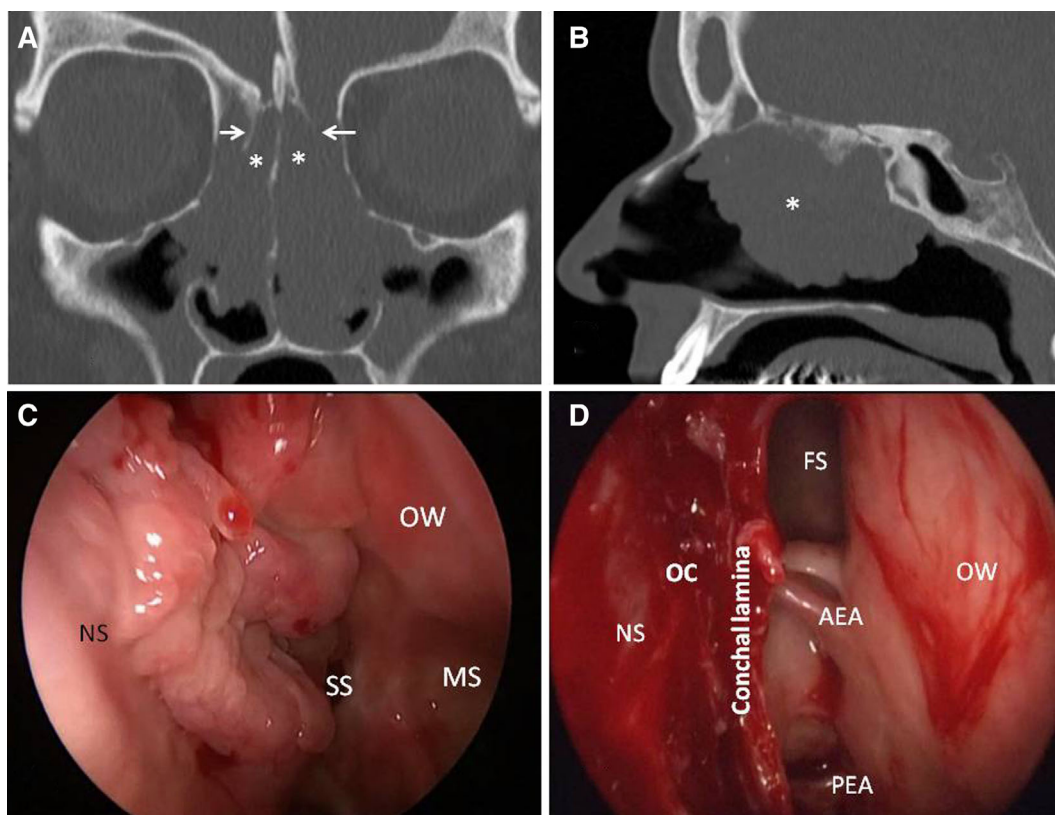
Patient with history of nasalization with middle turbinate resection and large opening of all paranasal sinuses 17 years ago. The first revision surgery was performed 17 years after nasalization. (A) Coronal CT scan before revision surgery showed voluminous polyps developing essentially inside the olfactory clefts (white asterisks) which were widened and pushed laterally the conchal lamina (white arrows); (B) Sagittal CT scan of the left nasal cavity showed voluminous polyps stemming from the olfactory cleft; (C) Per-operative endoscopic aspect of the left nasal cavity of this patient at revision surgery: huge polyps stemming from the left olfactory cleft; (D) Endoscopic aspect of the left nasal cavity after removal of polyps: polyps were observed only inside the olfactory cleft, the mucosa of left ethmoidal complex was free of polyp recurrence. Pathological results confirmed a huge REAH with some small inflammatory polyps. AEA = anterior ethmoidal artery; CT = computed tomography; FS = frontal sinus; MS = maxillary sinus; NS = nasal septum; OC = olfactory cleft; OW = orbital wall; PEA = posterior ethmoidal artery; REAH = respiratory epithelial adenomatoid hamartoma; SS = sphenoidal sinus.
